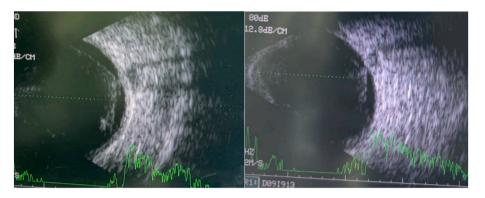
Ultrasound of the right eye demonstrating extensive tractional retinal detachment with vitreous and subretinal hemorrhage.
